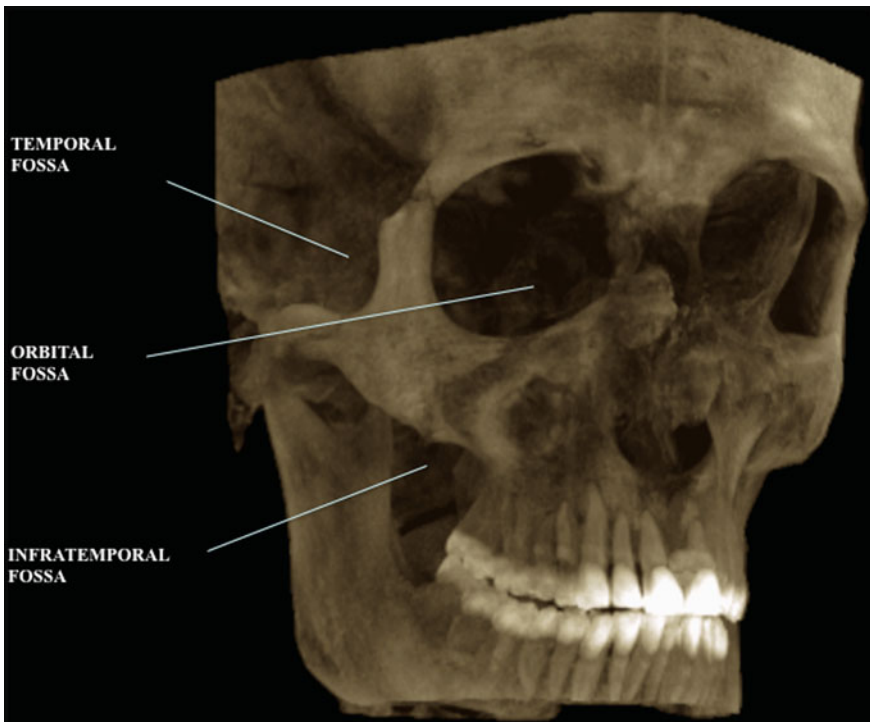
CBCT-3D reconstruction of the skull
